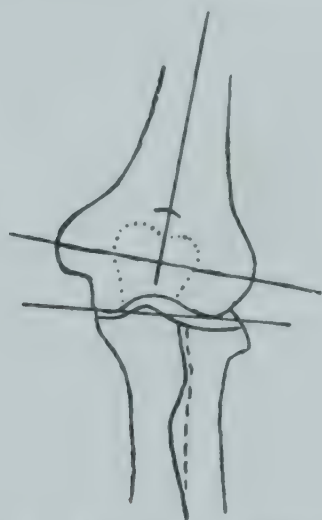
Carrying angle. (Sante, L. R.: Manual of Roentgenological Technique, Edwards Brothers.)
